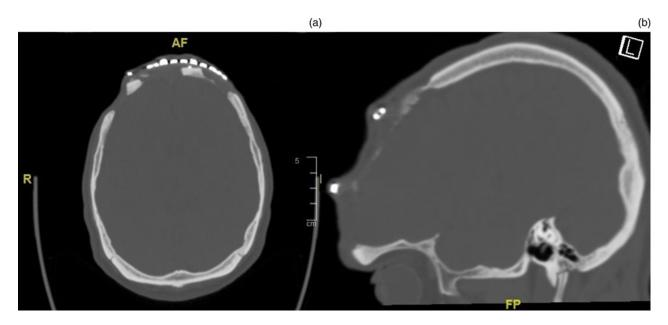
(a) Axial and (b) sagittal cone beam computed tomography scans after one year, showing new bone formation between the transport disc medially and the cranial calvarial bone laterally. AF = anterior/feet; R = right; FP = feet/posterior
